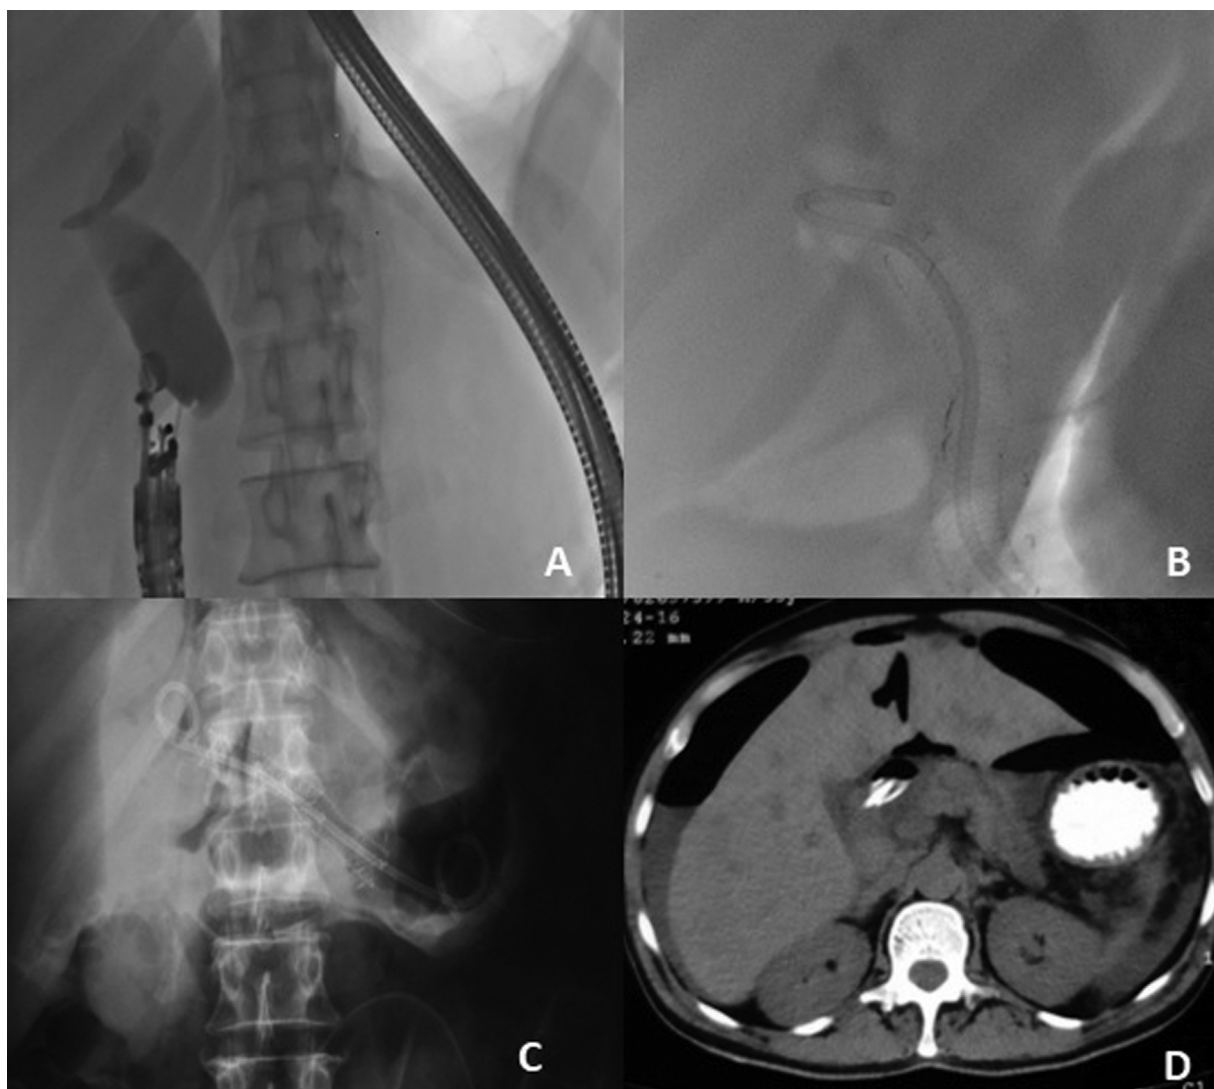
Distal migration of partially covered self-expanding metallic stents (SEMS) causing bile and duodenal leak. (A) Endoscopic ultrasound (EUS)-guided needle puncture of the bile duct. The contrast-filled common bile duct is dilated. (B) EUS-guided partially covered SEMS placed in the bile duct. A double pigtail plastic stent through the SEMS to prevent migration. (C) Distal migration of the SEMS. (D) Contrast-enhanced computed tomography abdomen: Distally migrated stent leading on to pneumoperitoneum.
